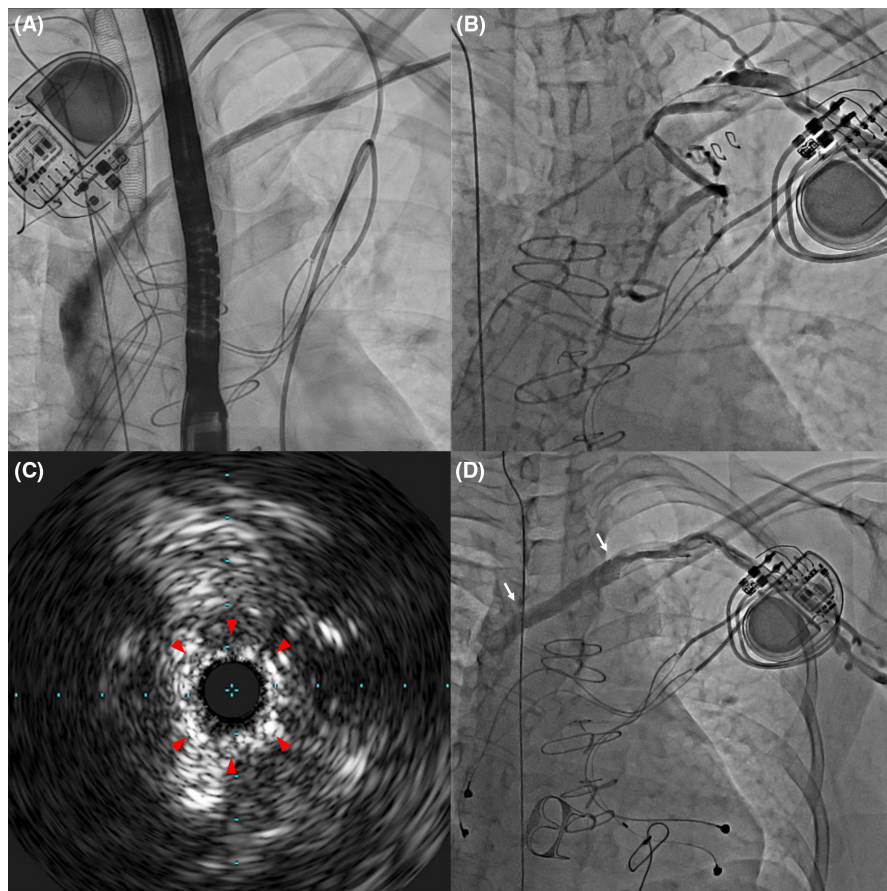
Venography was performed during the first session (A) and 1 week later (B). (C) Intravascular ultrasound reveals severe stenosis with circumferential calcification of the vein (arrowheads). (D) Postoperative venography reveals patency from the left subclavian vein to the superior vena cava and regression of the collateral flow. White arrows indicate the proximal and distal edges of the stent.
